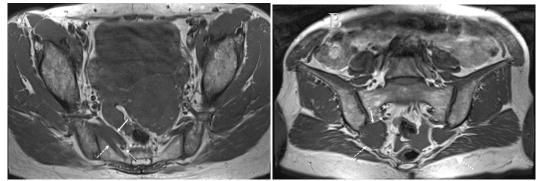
MRI Pelvis T1 weighted sequence. (A) Axial and (B) oblique coronal view shows an accessory piriformis muscle (solid arrow) anterior and superior to the right main piriformis muscle (dashed arrow). The right S2 nerve (dotted arrow) courses in between the belly of the main and accessory right piriformis muscles.
